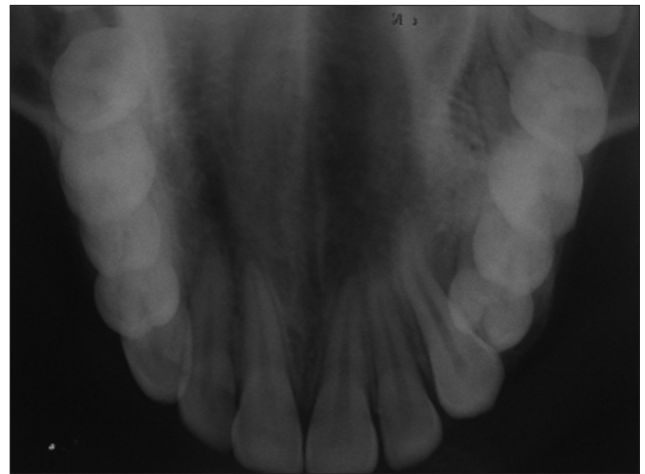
Maxillary cross-sectional occlusal radiograph showing cortical plates expansion
